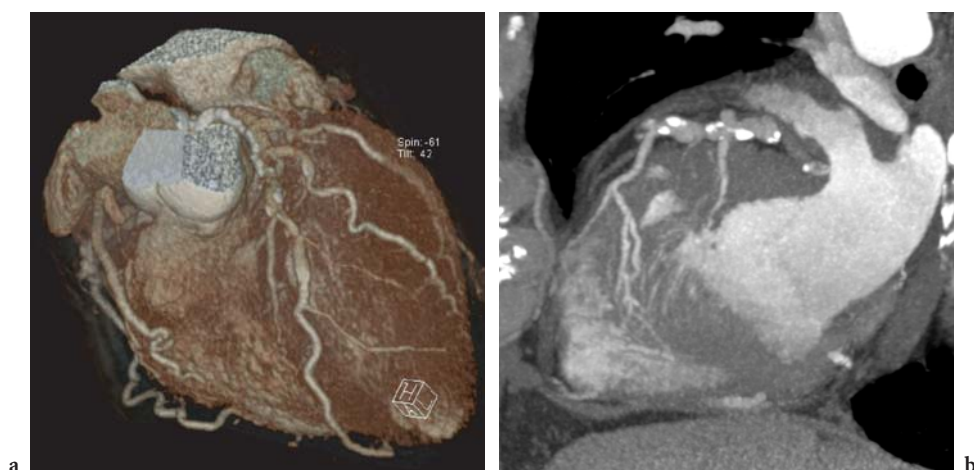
16-slice CT examination of a spider-like fistula from the LAD coursing through the interventricular septum and subepicardial to the right ventricle with multiple feeding vessels. Display with volume-rendering reconstruction viewed from the top (a) and with thin-MIP along a mid-ventricular short-axis section (b), showing the multiple fistulas through the interventricular septum to the right ventricle
